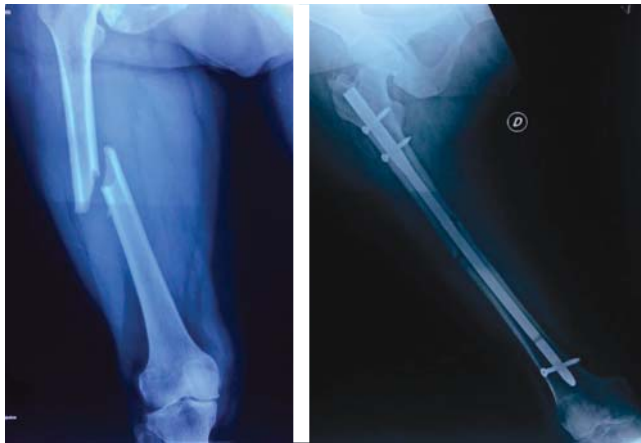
Initial radiograph (left side), continuity solution at femoral diaphysis is observed with oblique tract, dislodged, without comminution, and cortical thickening. One day after (right side) closed reduction internal fixation with antegrade locked intramedullary nailing.
